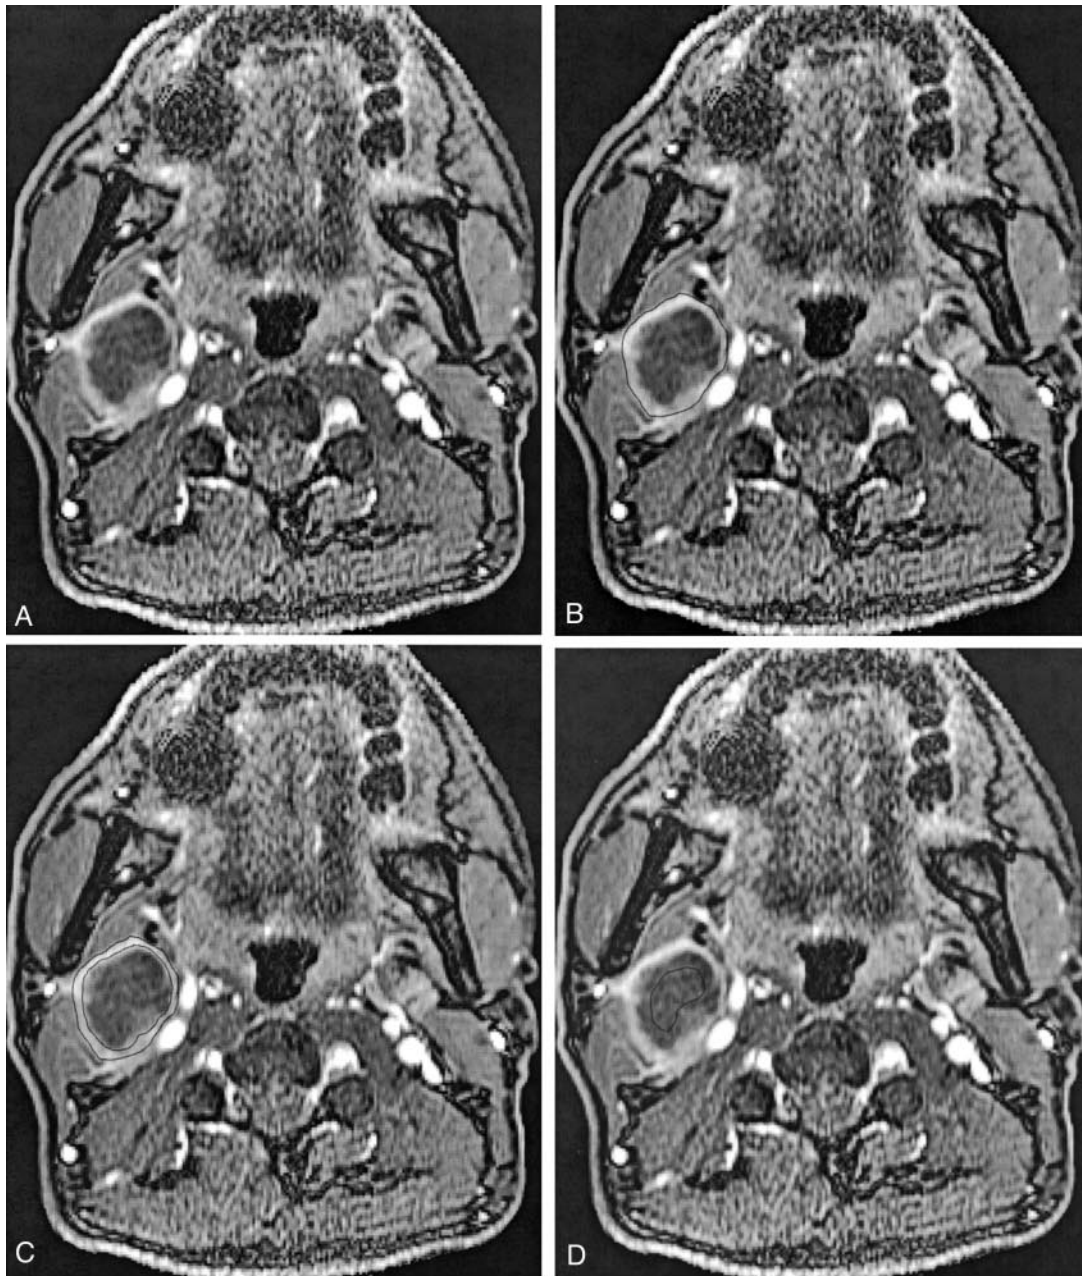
Patient 7, a 52-year-old man who had previously undergone partial glossectomy for squamous cell carcinoma of the tongue, received no additional therapy, and then presented with a palpable right neck mass. Fine needle aspiration confirmed recurrent squamous cell carcinoma in the neck, and MR imaging revealed right cervical necrotic lymphadenopathy. The patient then underwent re-excision of the primary site and a right radical neck dissection.
